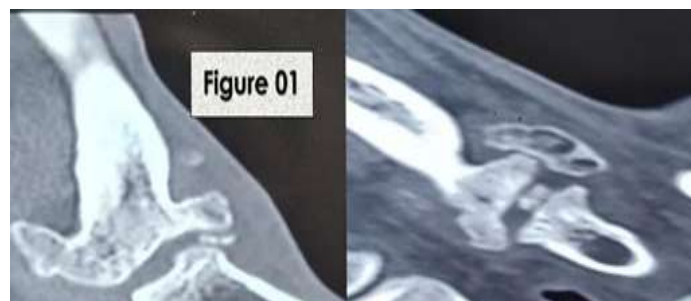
Pre-operative radiograph showing complete flattening of the 2nd metatarsal head, intra-articular loose bodies, and MTP osteoarthritis — Smilie Stage 5.
